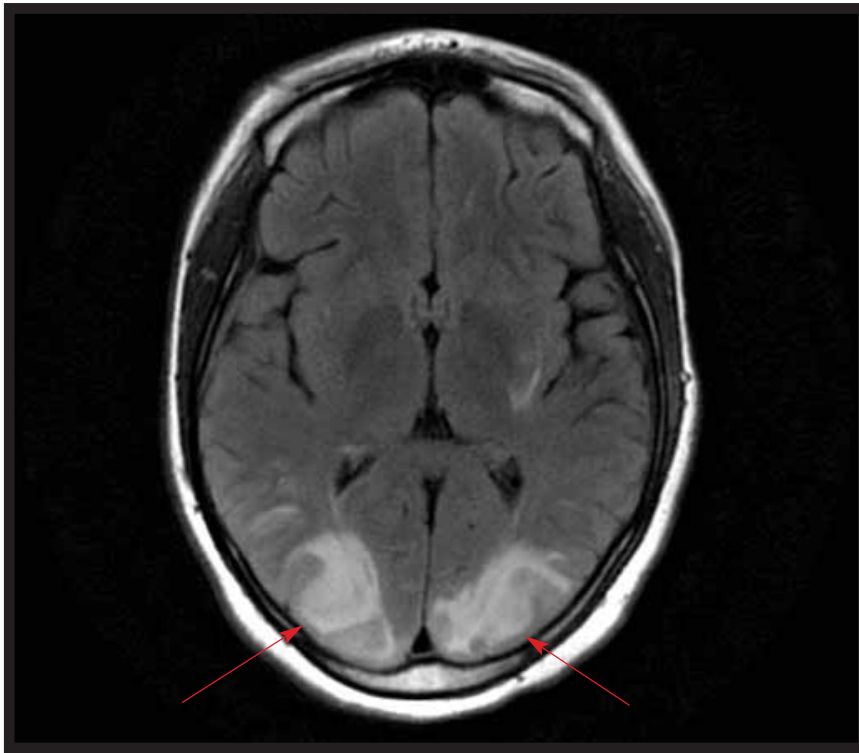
Hyperintense signal within the white matter tracts of the parieto-occipital lobes posteriorly and bilaterally (arrows) is seen on fluid-attenuated, inversion recovery T2-weighted MRI.
